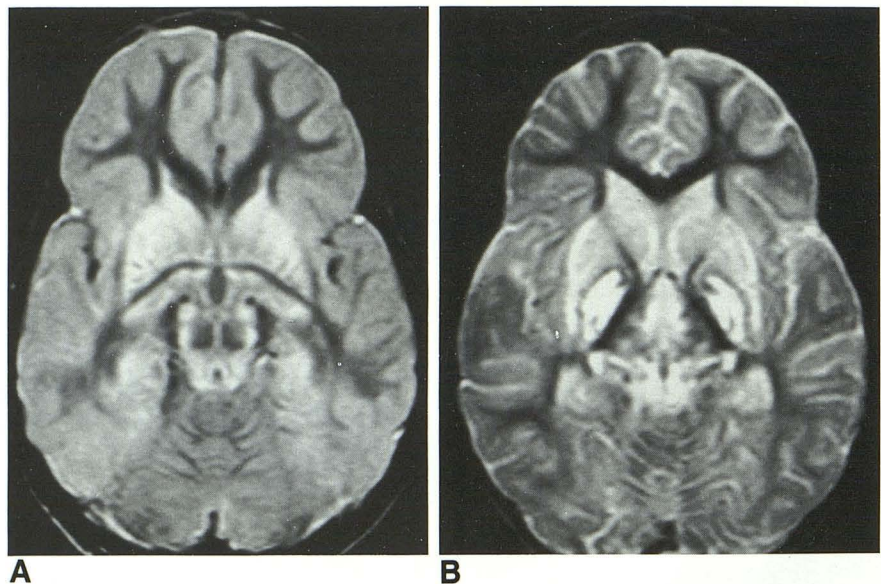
A 3-year-old boy nearly drowned in a swimming pool at home. CT scan (data not shown) demonstrated the so-called "white cerebellum" and bilateral hypodensity of the pallidum. Proton density axial MR (A) and T2-weighted axial MR (B) through the basal ganglia show nearly symmetrical involvement of the caudate nuclei, the putamina, the globi pallidi, the thalami, the geniculate bodies, the gray matter in the wall of the third ventricle, and the periaqueductal gray matter. Extensive cortical laminar necrosis is observed.
